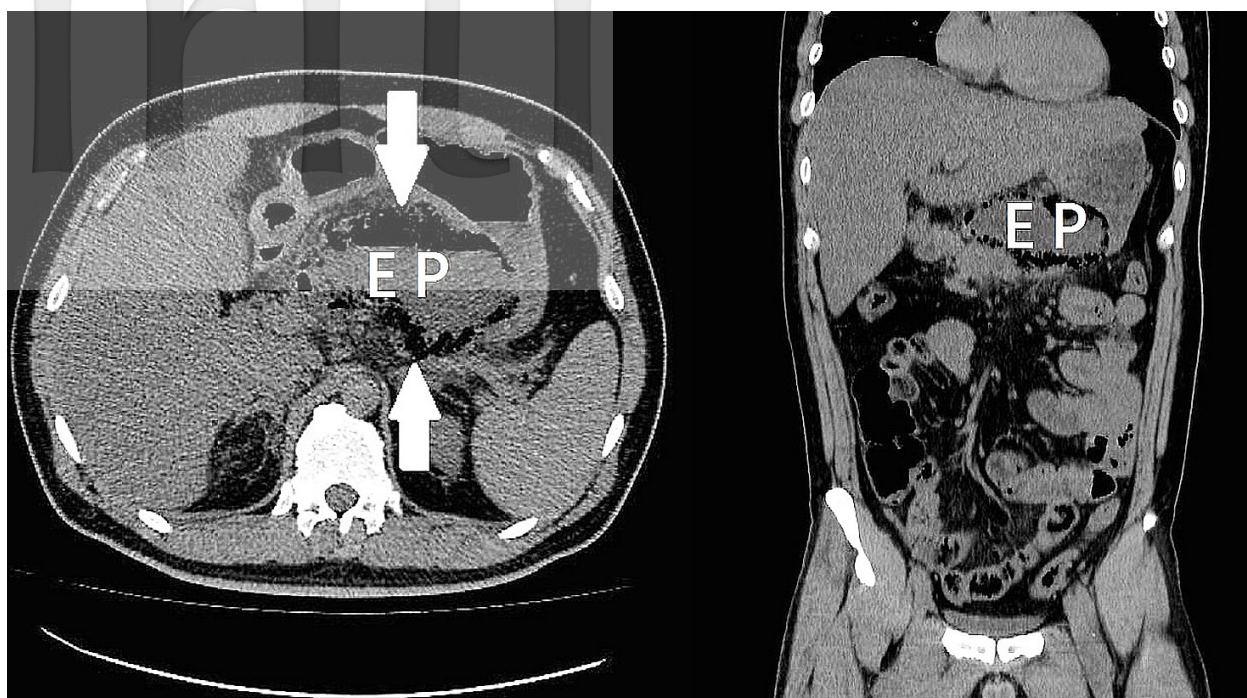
The computed tomography (CT) of abdomen (horizontal transection view A, coronal view B) revealed swollen of the pancreas with diffuse peri-pancreatic air density in the pancreatic body and tail indicating emphysematous pancreatitis (EP).
